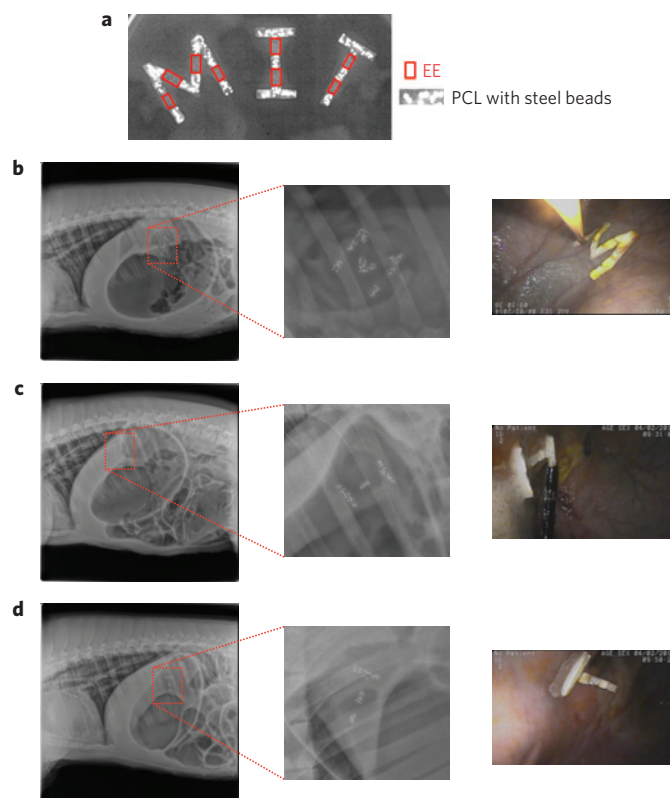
In vivo* evaluation of M-shaped (30 mm × 30 mm × 4 mm), I-shaped (30 mm × 18 mm × 4 mm) and T-shaped (30 mm × 18 mm × 4 mm) devices. a, X-ray image of M-, I-, and T-shaped devices made of EE and PCL with embedded steel beads as X-ray contrast agent. b–d, X-ray images (left and middle) and endoscopic image (right) showing gastric retention of M-shaped (b), I-shaped (c) and T-shaped (d) devices.
